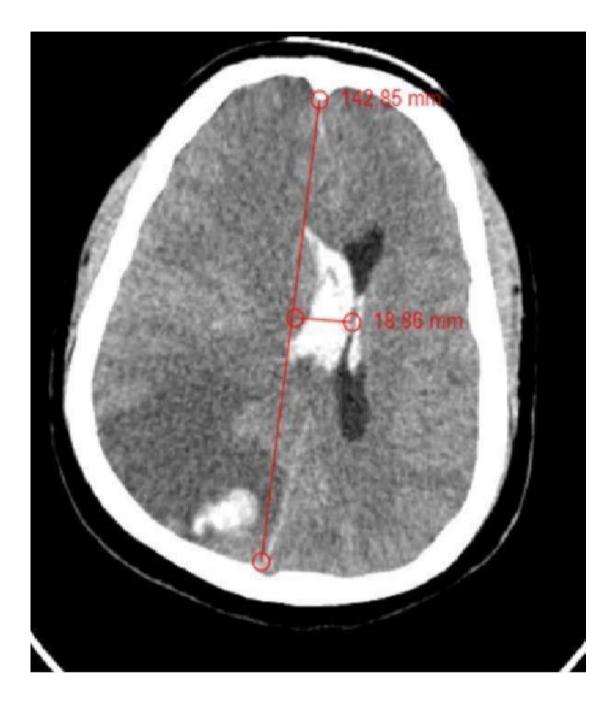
Axial non contrast enhanced brain CT showing acute Intra-cerebral hematoma in the right parietal lobe causing mass effect over ipsilateral lateral ventricle and midline shift of 18.8 mm to left
